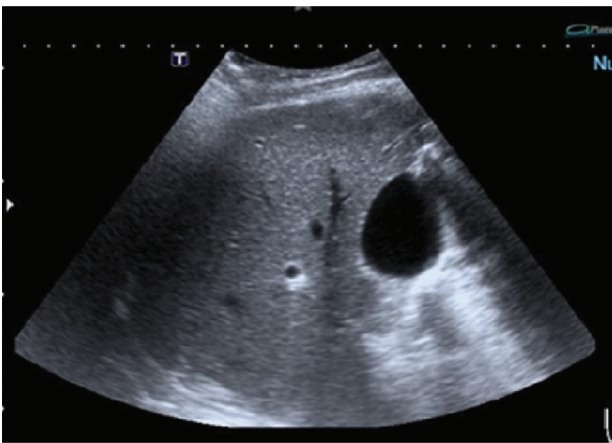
Ultrasound of hepatic Doppler control showing changes in hepatic echogenicity and absence of lesions.
